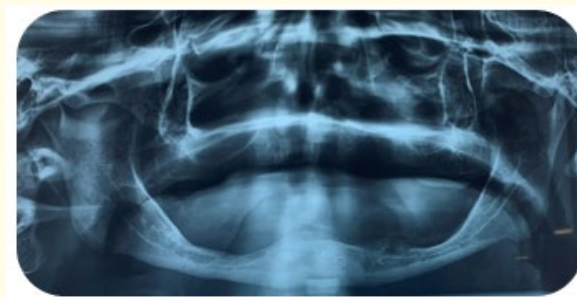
Panoramic radiograph of the patient showing no pathological radiological findings.
